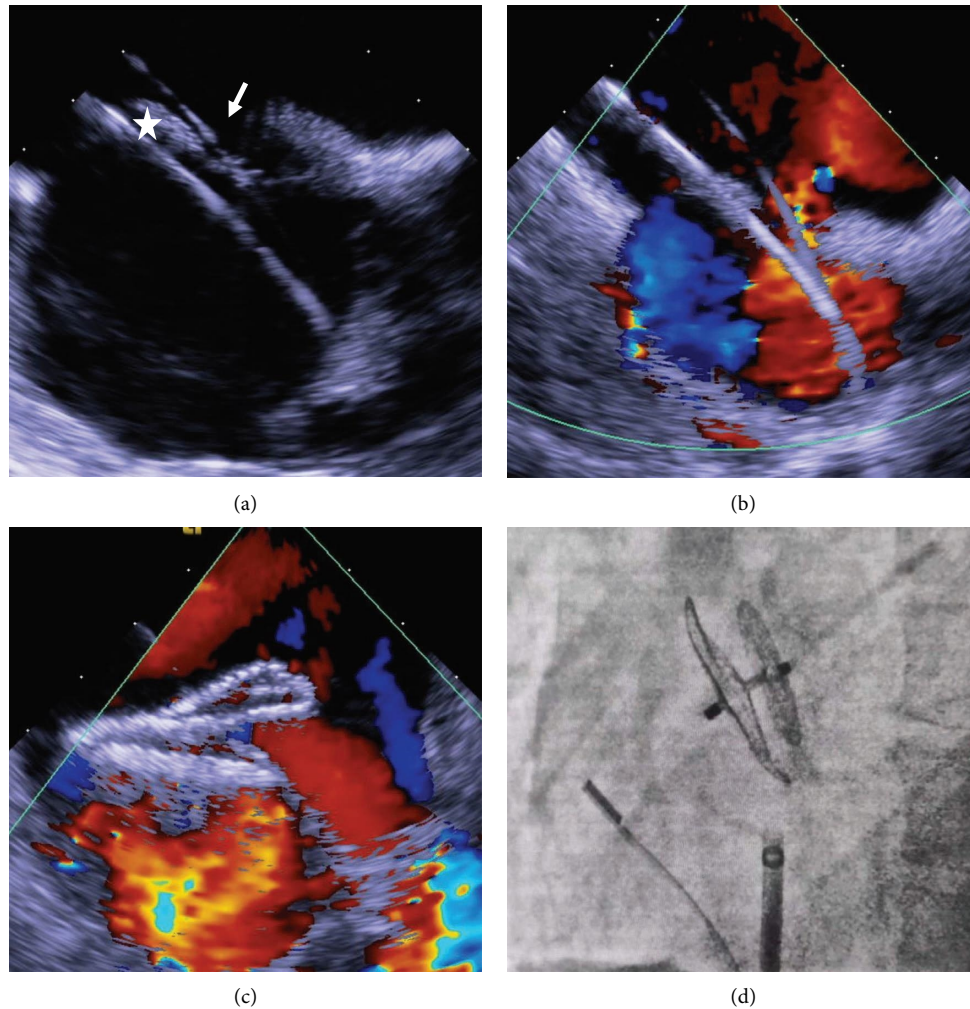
Transcatheter closure of the PFO and adjacent ASD under ICE and X-ray fluoroscopy guidance. (a) Atrial septal defect (arrow) and foramen ovale (asterisk) on ICE two-dimensional imaging. (b) Left-to-right shunting at atrial septal defect on ICE Color Doppler Flow Imaging. (c) No residual shunting after occluder closure. (d) Percutaneous PFO closure with the double disk device guided by X-ray fluoroscopy. ASD, atrial septal defect; ICE, intracardiac echocardiography; PFO, patent foramen ovale.
